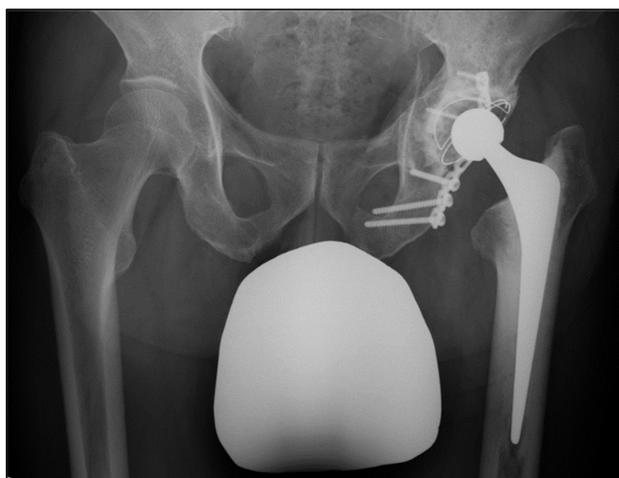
X-ray after the first surgical intervention
